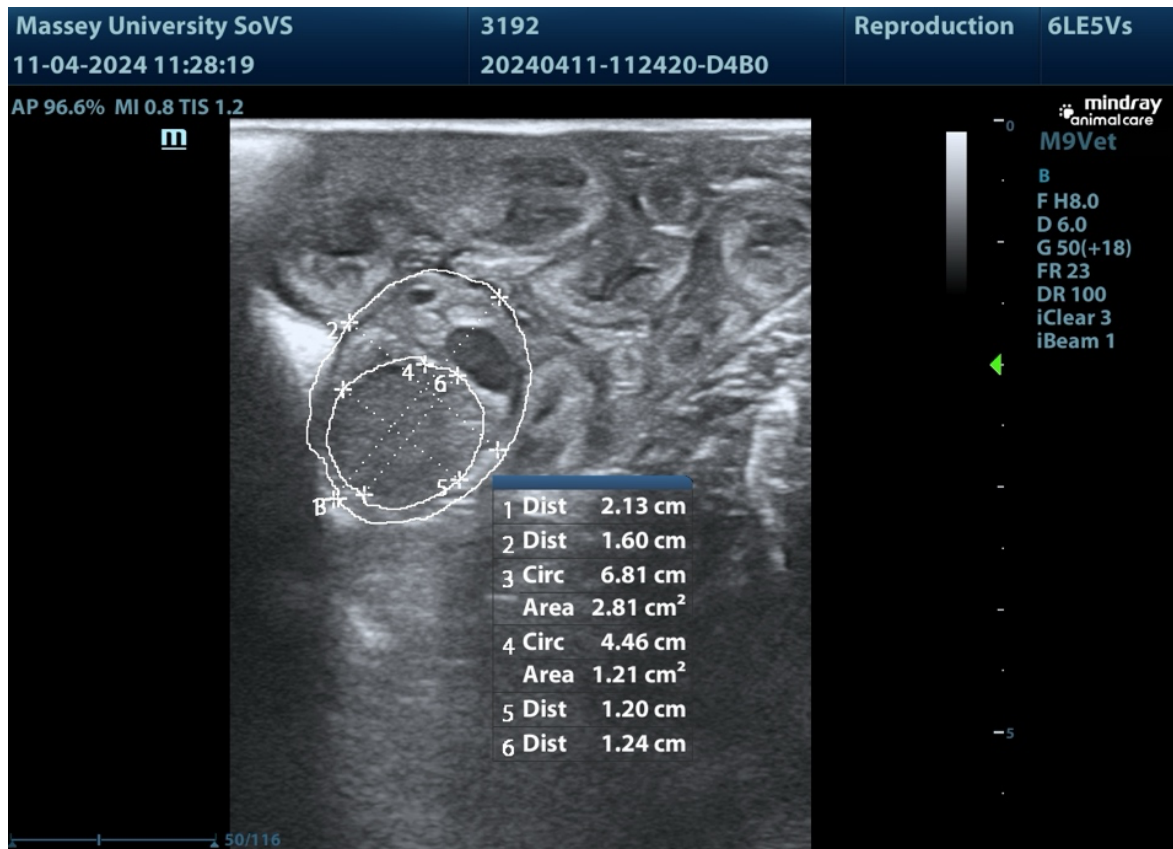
Ultrasound image of ovarian follicles in ewe lamb 3192. This image shows the measurements of the ovary, the follicles and a corpus luteum present within the ovary. Measurements taken included the diameter, area and circumference.
